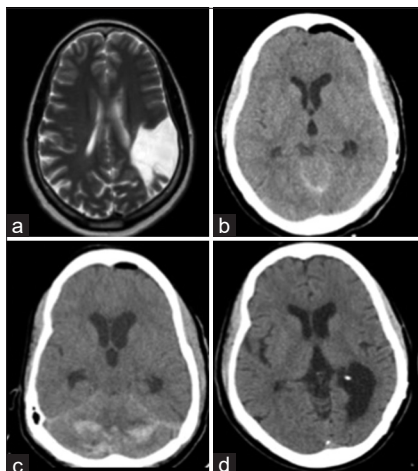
(a) Pre-operative head MRI demonstrating a left parietal arachnoid cyst without hydrocephalus. (b) Immediate post-operative CT with no signs of hydrocephalus. (c) Head CT demonstrating acute hydrocephalus during post-operative period. (d) Last follow-up head CT without signs of hydrocephalus.
